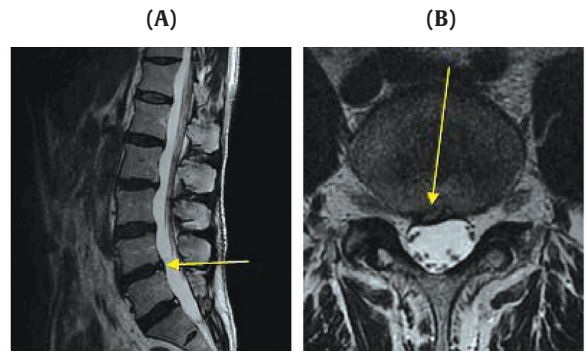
Lumbar spine MRI (T2-weighted image) of Case 2 on July 25, 2018. (A) Sagittal (B) Axial L4-5. MRI, magnetic resonance imaging.
